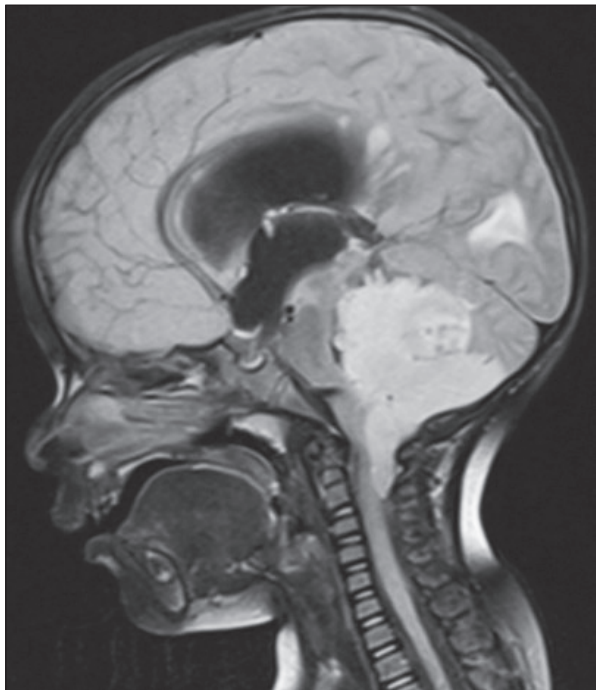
Cervicomedullary tumor exceeding the decussation pyramidalis and occupying the fourth ventricle, causing hydrocephalus in sagittal MR image [image(s) courtesy of the authors' archive].
